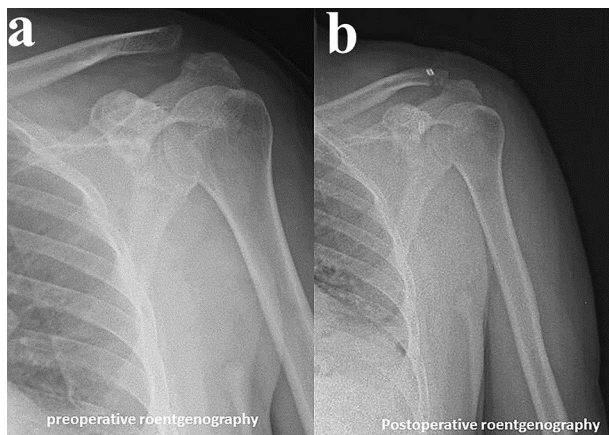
Grade III acromioclavicular joint dislocation stabilized with endobutton system. a: Preoperative roentgenography, b: Postoperative roentgenography
